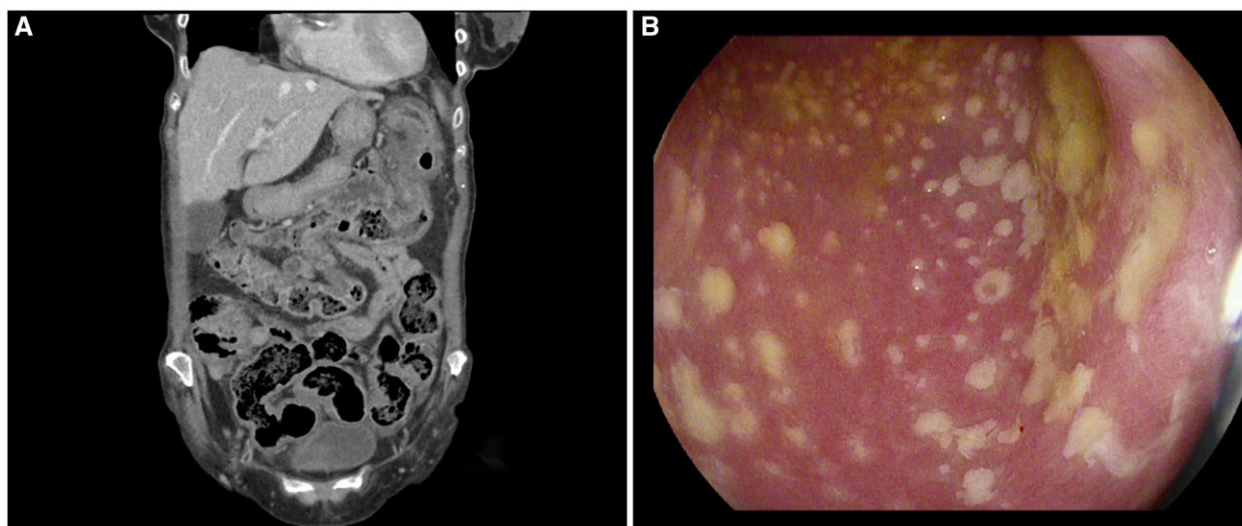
Images of the patient with (A) an abdominal CT scan showing diffuse circumferential wall thickening (consistent with submucosal edema) of the entire colon and (B) a colonoscopy image showing the characteristic white–yellow, elevated plaques converging to pseudomembranes on the mucosa.
